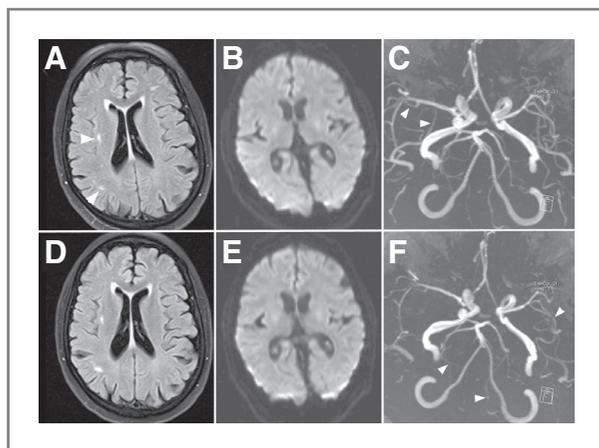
MRI of the brain of a 55-year-old woman with lymph node metastasis of recurrent ovarian cancer and horizontal diplopia before (A–C) and 3 hours after (D–F) the administration of OXi4503. Axial T2 FLAIR (A and D), diffusion weight scans (B and E), and time-of-flight MRI angiograms (C and F) are shown. Less distension particularly of branches of the anterior and middle cerebral arteries and of the cerebellar and vertebral vessels is seen. Arrowheads in A indicate old, small, probably ischemic lesions in the middle and posterior cerebral artery territories that remain unchanged. Arrowheads in C are branches of the right middle cerebral and in F of the left middle cerebral and cerebellar arteries.
